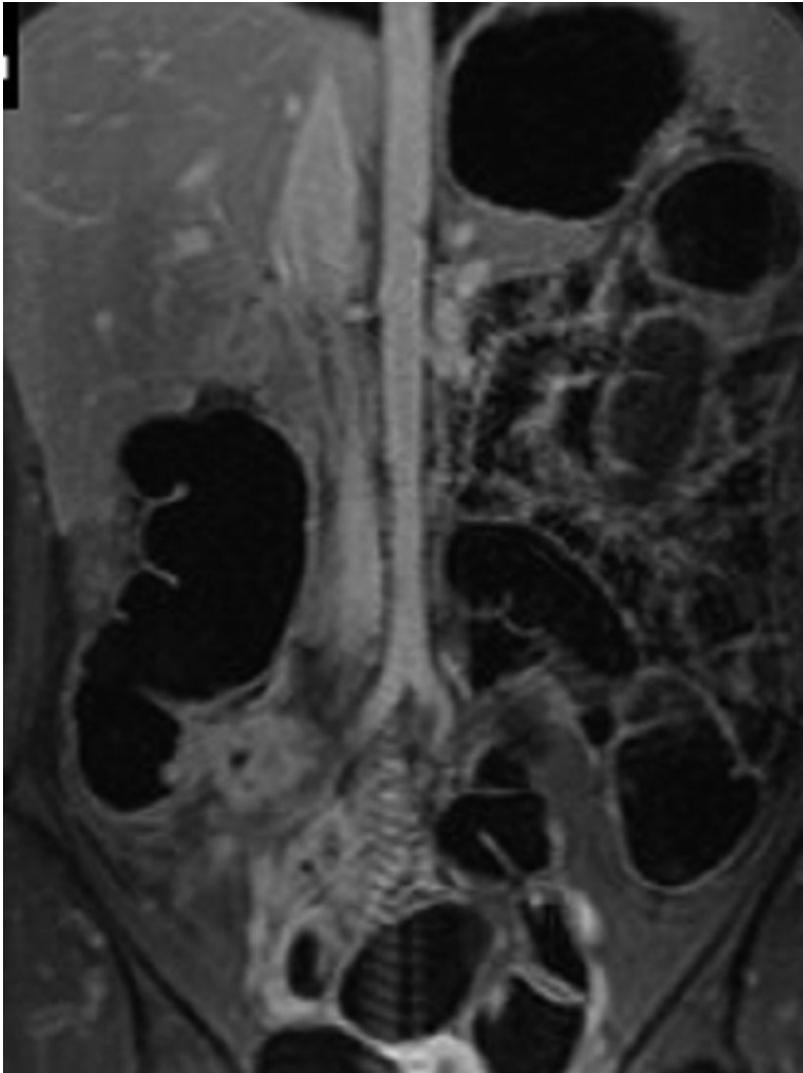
Additional rectal enema in hydro-MRI-exam of a 31-year-old female patient with known Crohn's disease. The colonic segments show a sufficient distension after rectal enema. The thickened wall of the terminal ileum shows an increased contrast uptake (arrow). Subsequent endoscopy and biopsy confirmed the presence of an acute inflammation of the terminal ileum.
